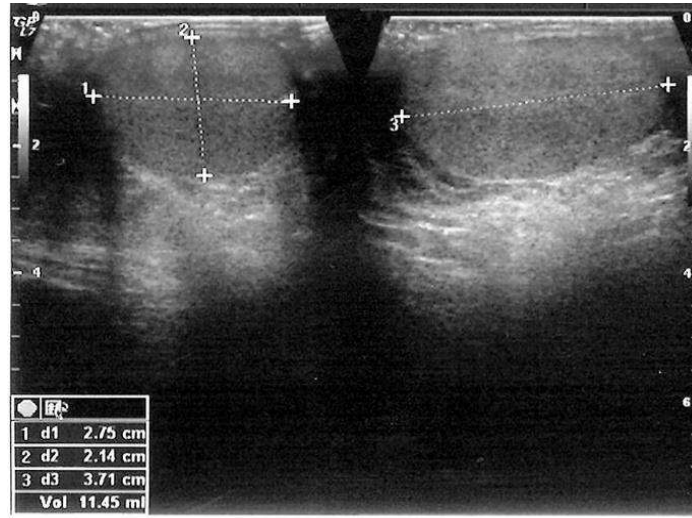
Sagittal and transverse gray scale ultrasound images demonstrate testicular volume measurement in a 44 year-old patient.
